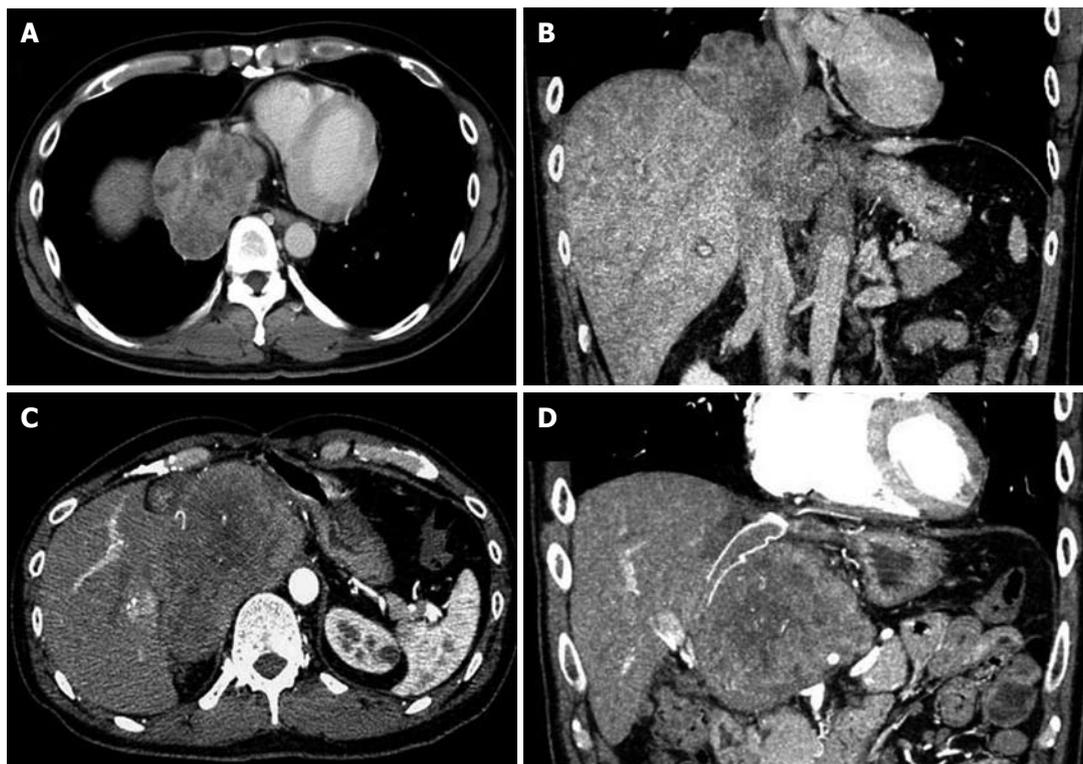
CT of the patient, showing the liver tumor infiltrating the suprahepatic inferior vena cava (A: Axial scan; B: Coronal scan), and showing the recurrent tumor (C: Axial scan; D: Coronal scan).
